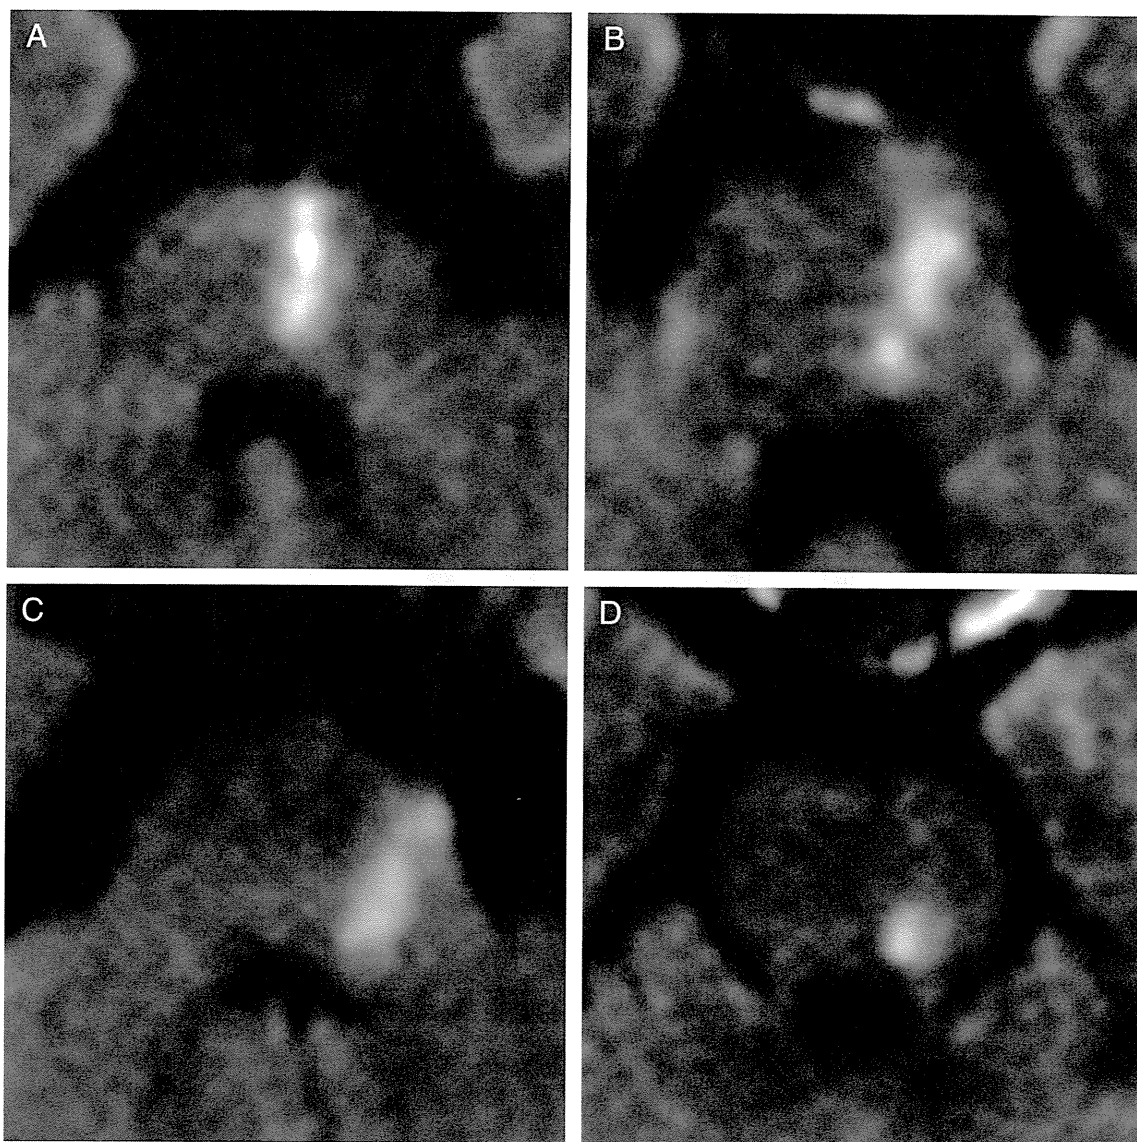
Pontine infarct locations based on DWI. A: anteromedial pontine infarct. B: anterolateral pontine infarct. C: lateral pontine infarct. D: posterior pontine infarct.
